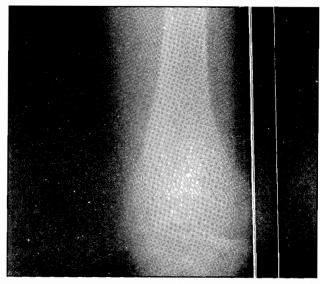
Xray of the right knee joint showing linear sclerotic bands osteopathia straita
